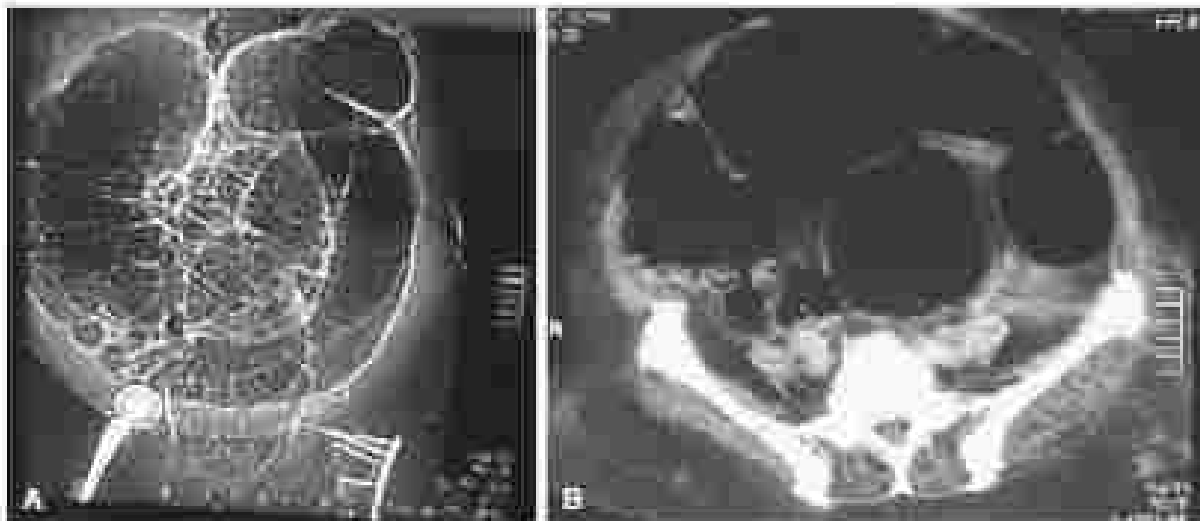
CT scans showing marked dilation of the colon without significant wall thickening or suggest ischemia and without free air.
